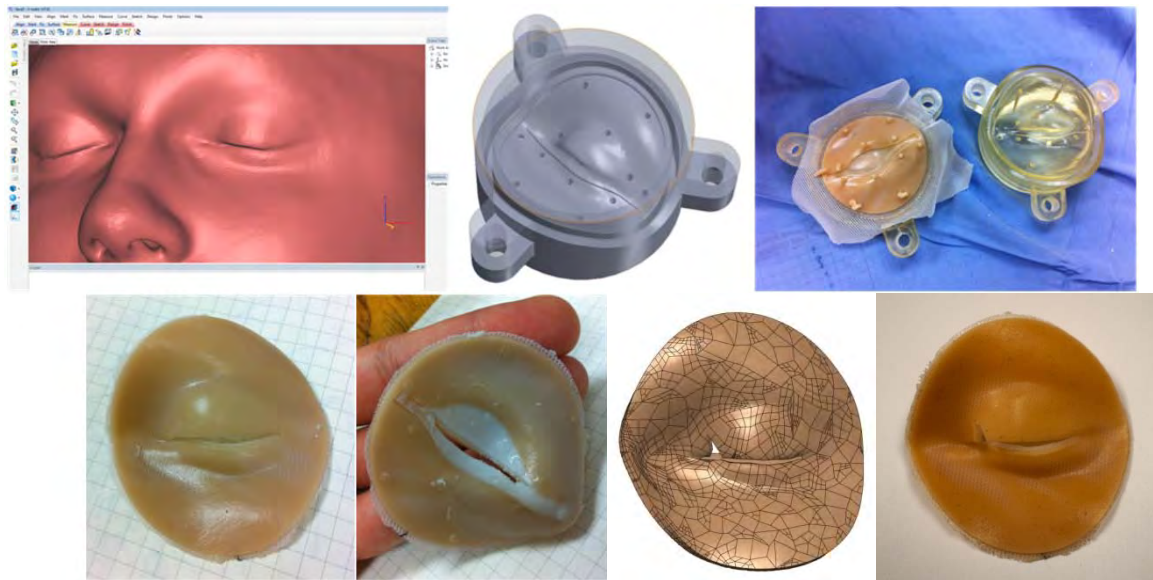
Eyelid based on CT-derived data: (top row) Mimics software view of anatomy, CAD model of mold, partially completed eye lid, prior to over-molding of tarsal plate. (bottom row) Front and back views of overmolded portal structure, CAD model with laceration, physical test model with defined laceration molded-in.
